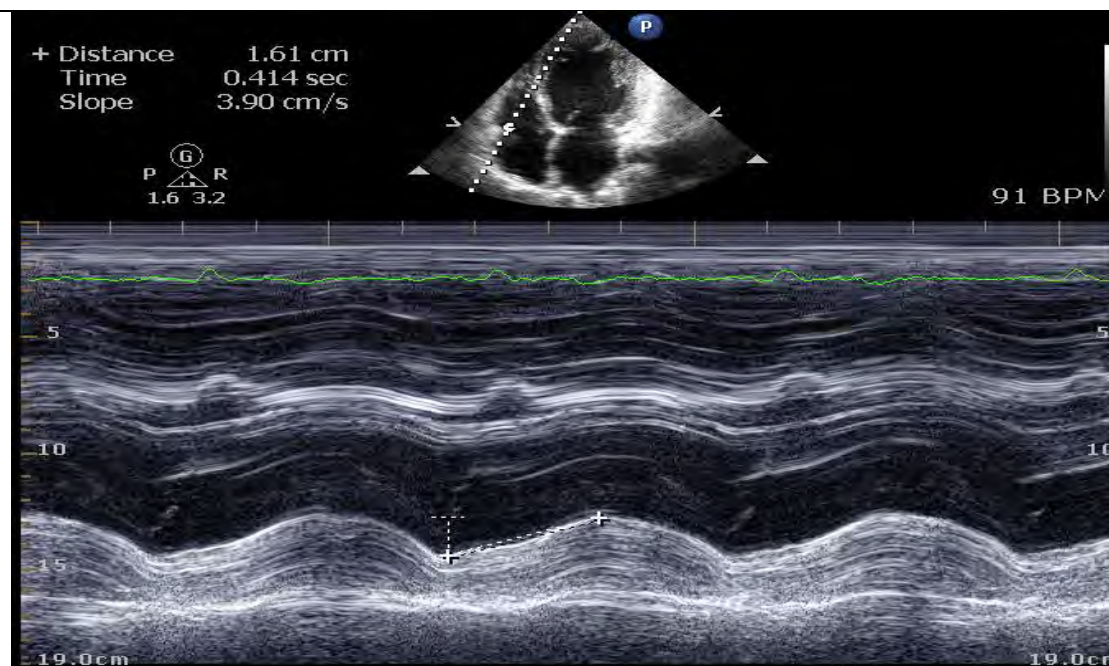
Apical four-chamber view with M-mode cursor at the tricuspid annulus. Bottom Image: M-mode image showing measurement of the tricuspid annular plane systolic excursion (TAPSE)
